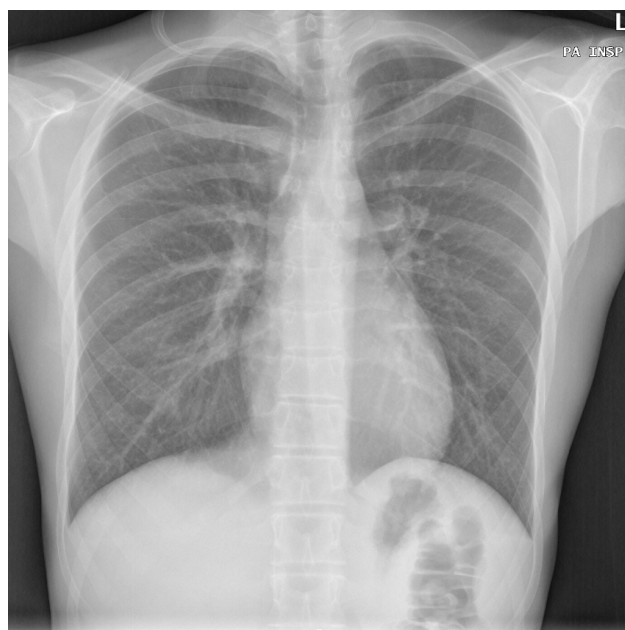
Posteroanterior chest radiograph after chest tube removal with no evidence of pneumothorax recurrence.
